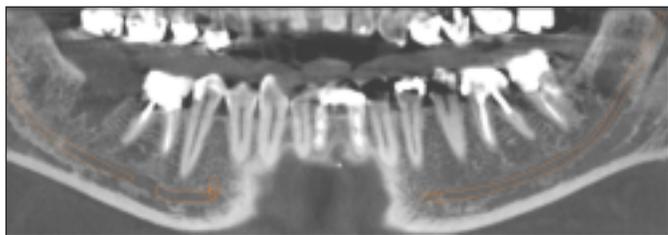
CBCT full-mandible panoramic view (non-focused field) at 24 hours post-extraction, showing newly grafted socket, position No. 31.
